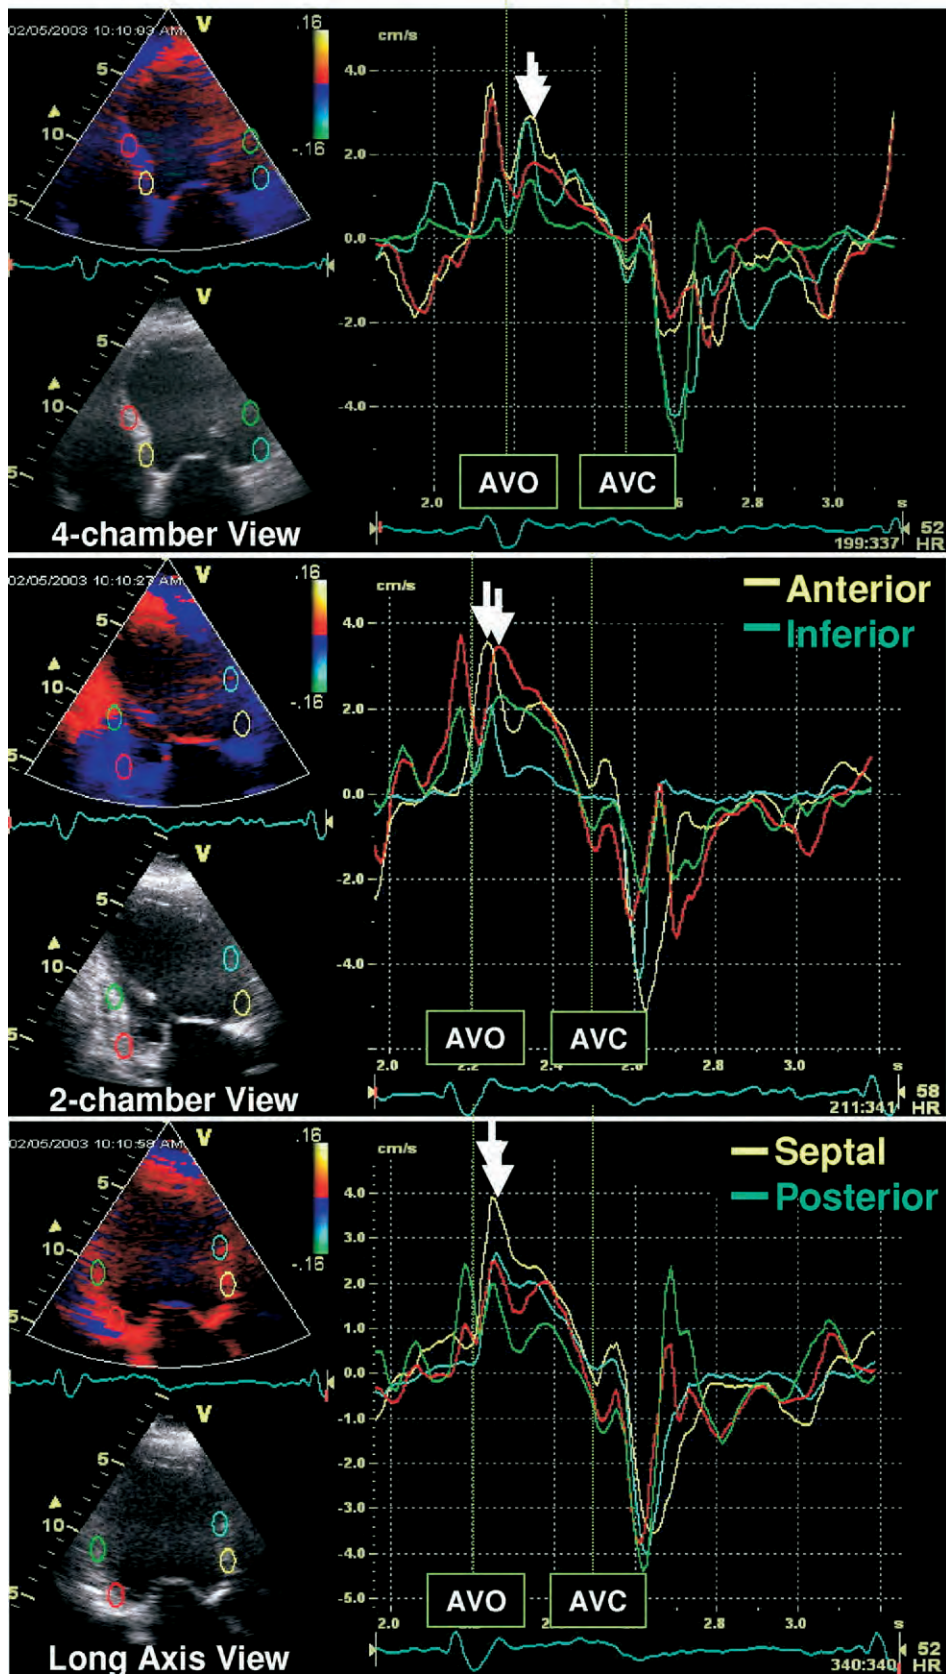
Color-coded tissue Doppler study from 3 standard apical views of patient who did not respond to resynchronization therapy. Time-velocity curves from both basal and midlevels show no significant opposing wall delay less than 65 milliseconds.
